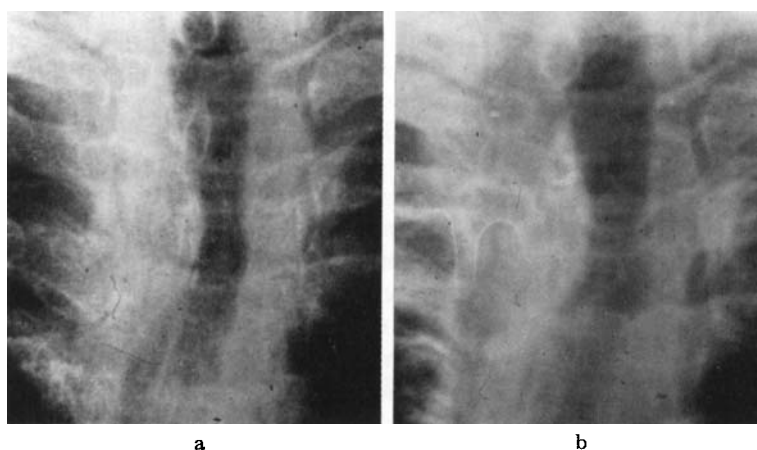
Doses of $50 + 25$ mC of ^{131}I given over 15 months. Roentgenograms of soft tissues of the neck: a) before treatment, b) six months after the last dose.
